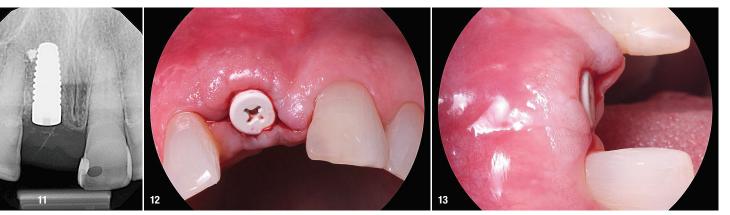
Final radiograph verification of implant placement 1.5 mm from the adjacent tooth and outside of the nasopalatine canal. Fig. 12: Uncovering of the implant and healing abutment placed. Fig: 13: Uncovering of the implant (buccal view), showing robust tissue health with no grey show-through of the material.
